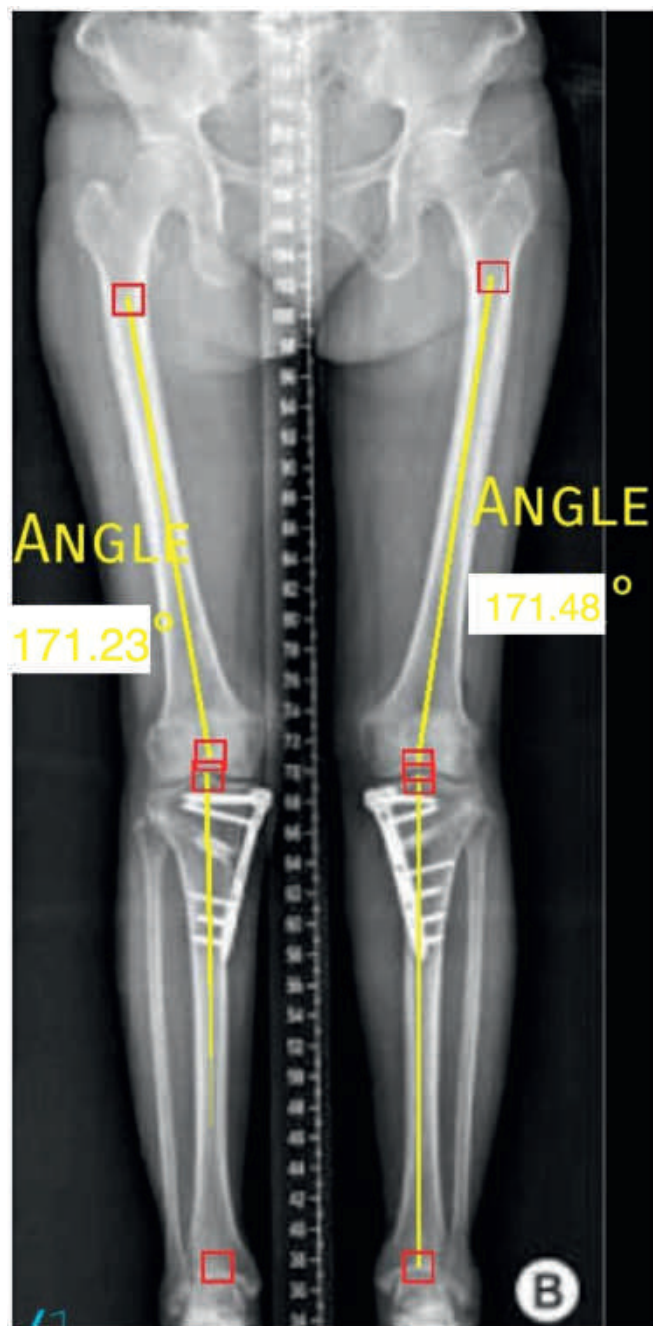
Post Op Hip Knee Ankle Xray showing correction achieved with Tomofix in situ.
